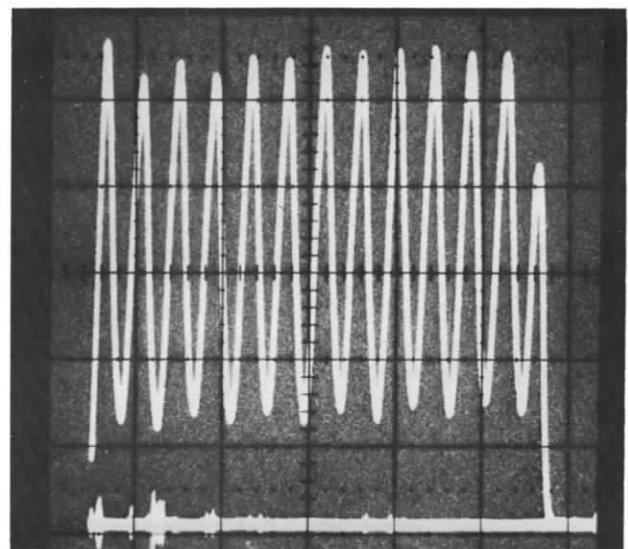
One of three phases missing in x-ray output waveform.
